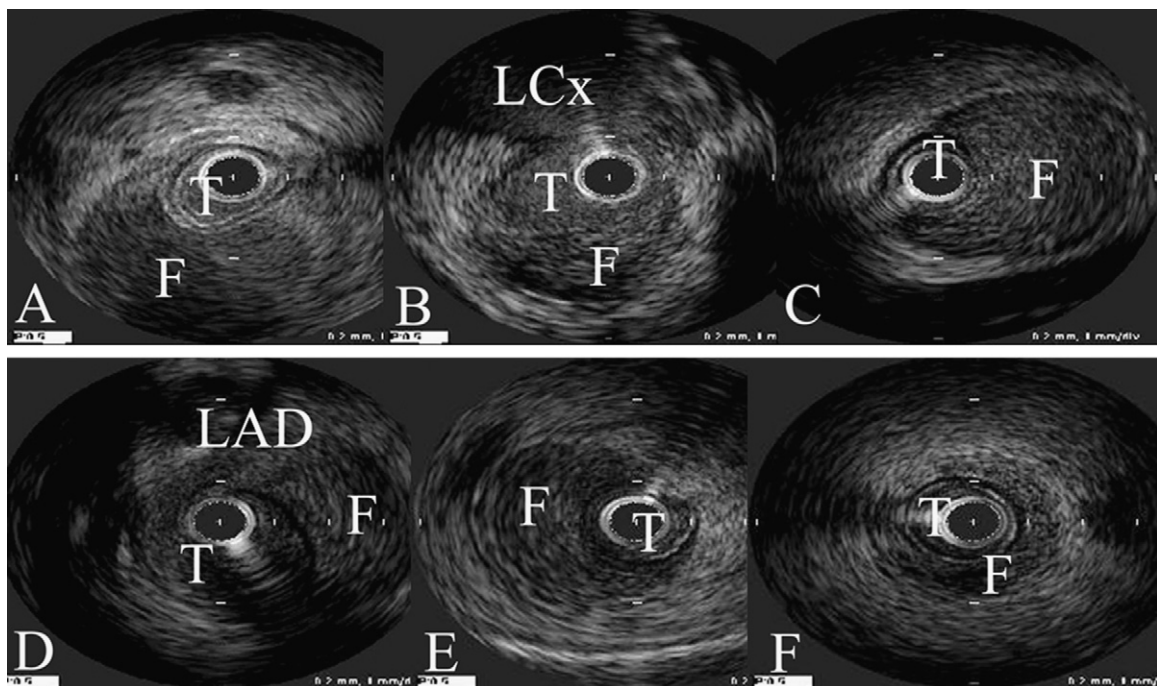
Intravascular ultrasound showing a dissecting intramural hematoma in a false lumen [F] and collapse of the true lumen [T]. (A) The distal LAD, (B) the proximal LAD, (C) the distal LCx, (D) the proximal LCx, (E) the distal RCA, and (F) the proximal RCA.
